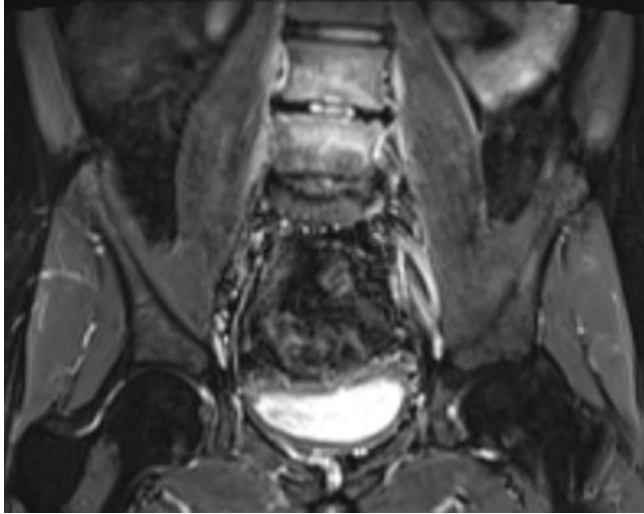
Pre-Operative MRI Pelvis / Bilateral Hips. High intensity signal changes at L4/L5 vertebrae and disc concerning for infectious collection.
